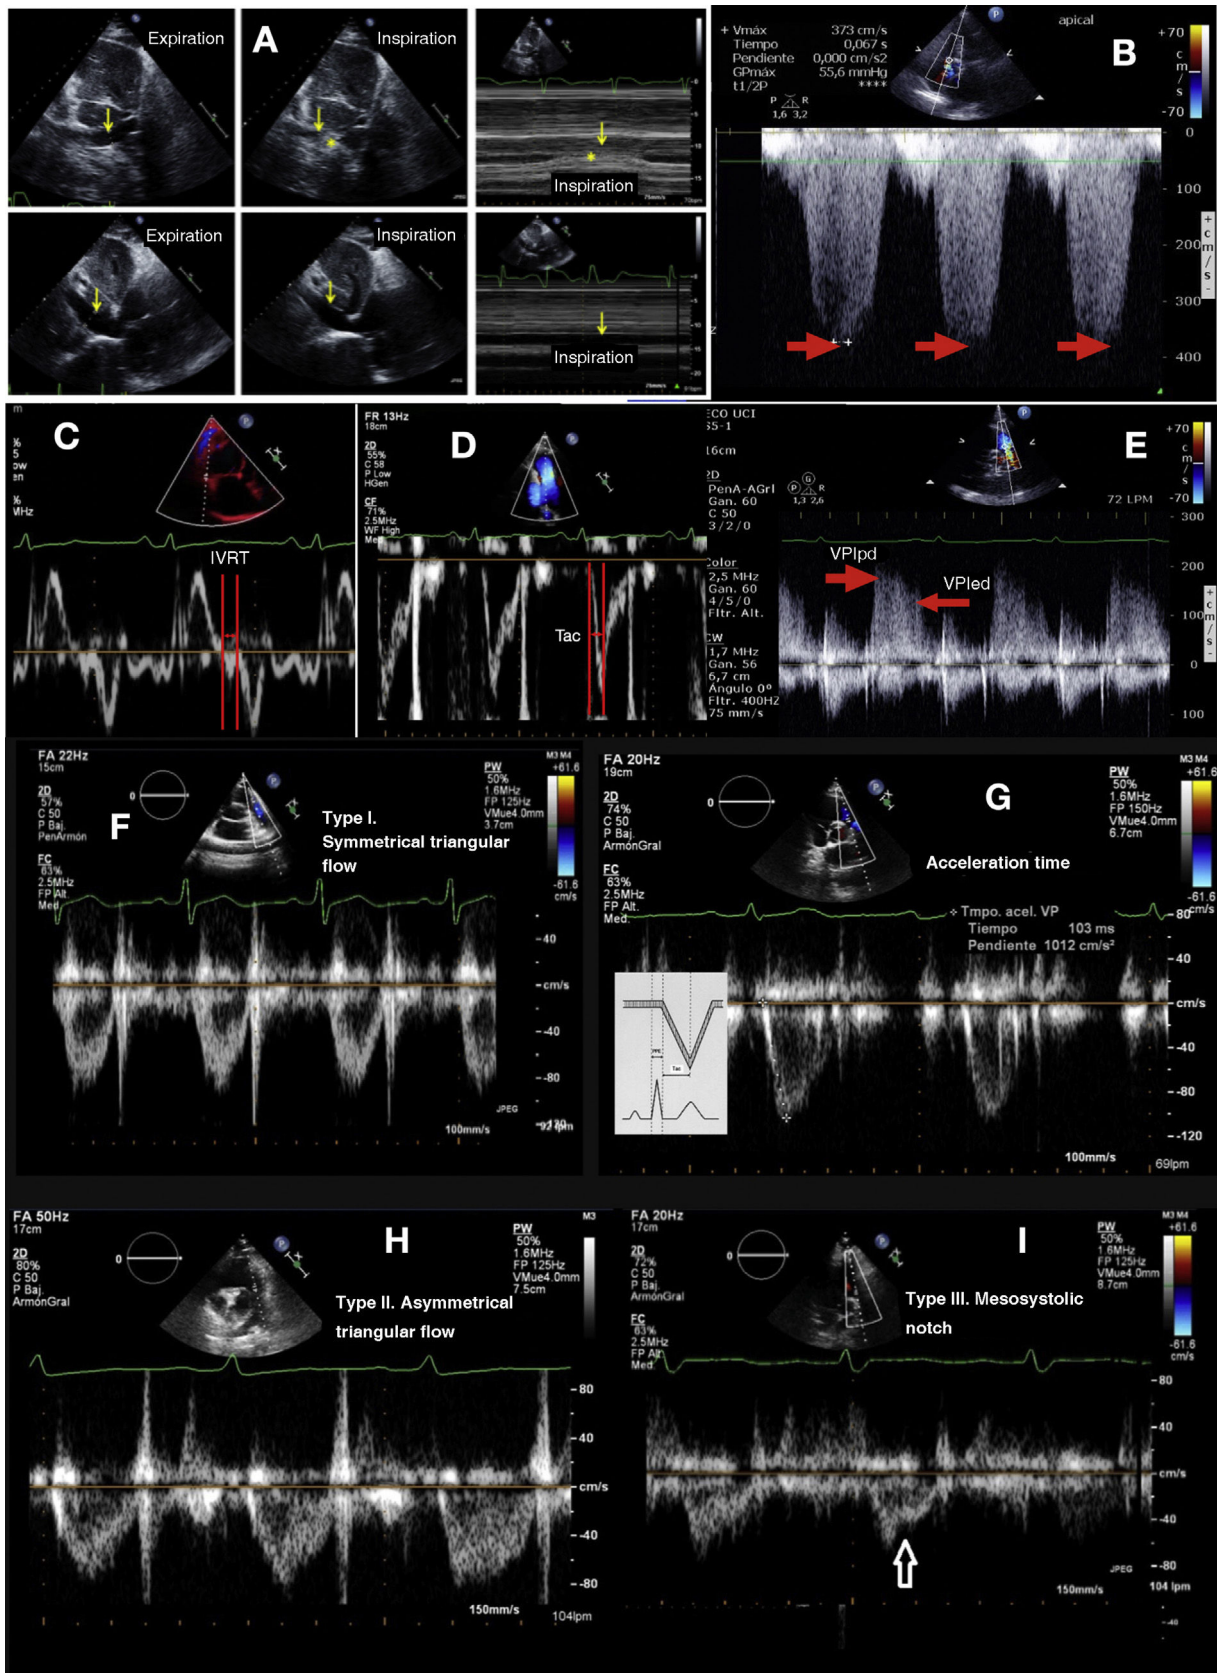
A. Variation of the inferior vena cava. The 2D inspiration and expiration image is shown in M mode. B. Continuous Doppler recording of tricuspid insufficiency. The red arrow indicates tricuspid insufficiency maximum velocity. C. Isovolumetric relaxation time (IRT). D. Pulmonary artery acceleration time (Tac). E. Pulsed Doppler recording of pulmonary insufficiency. The arrows indicate
